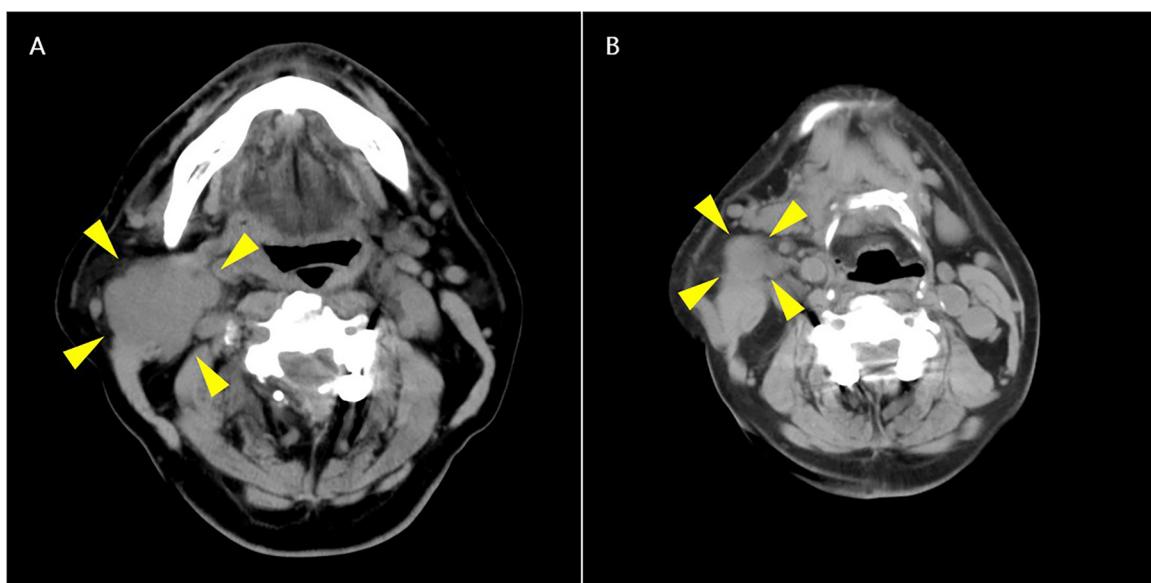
Computed tomography imaging.
